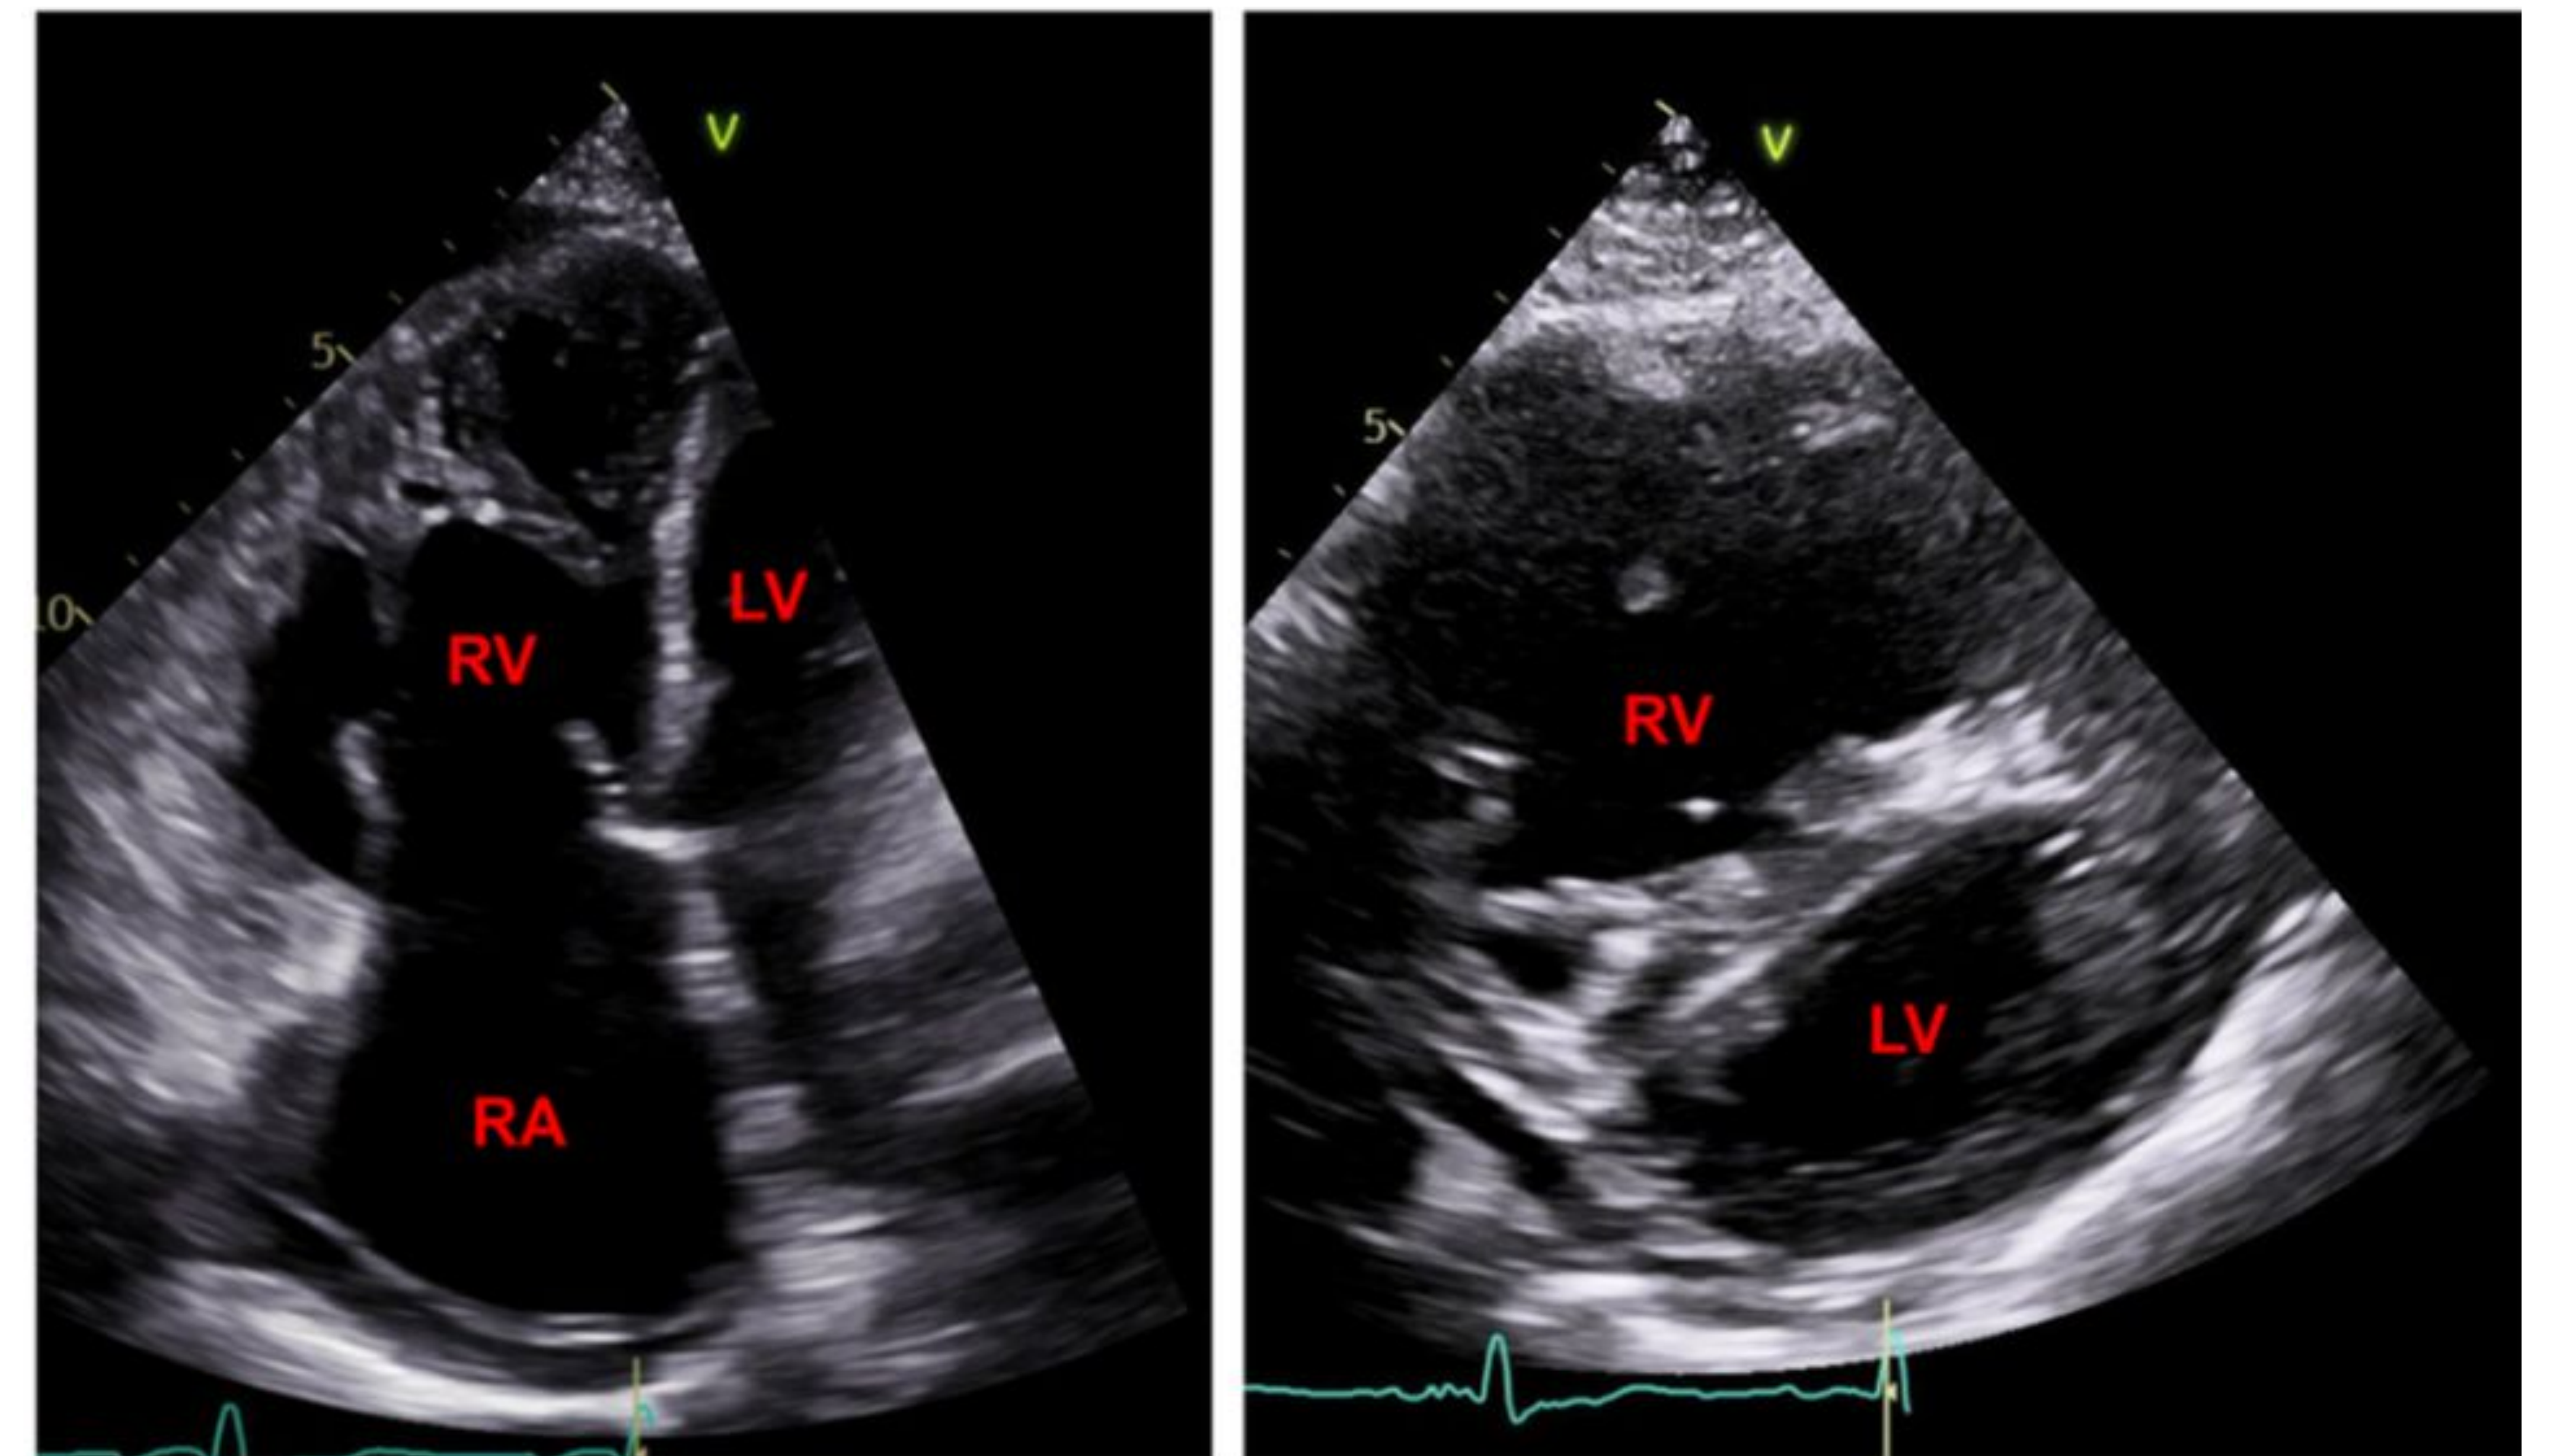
Transthoracic echocardiography demonstrating a dilated right ventricle (RV), right atrium (RA) and flattening of the interventricular septum, as seen in PH
